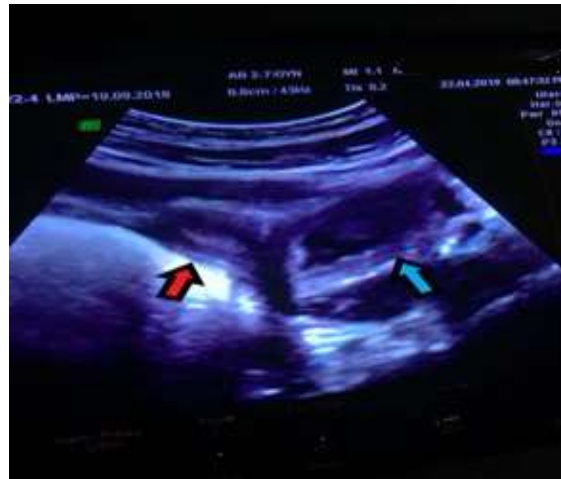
Pelvic ultrasonography image showing double uterine cavity and 25 mm fluid collection with diffuse low-level internal echo in the left uterine cavity.
